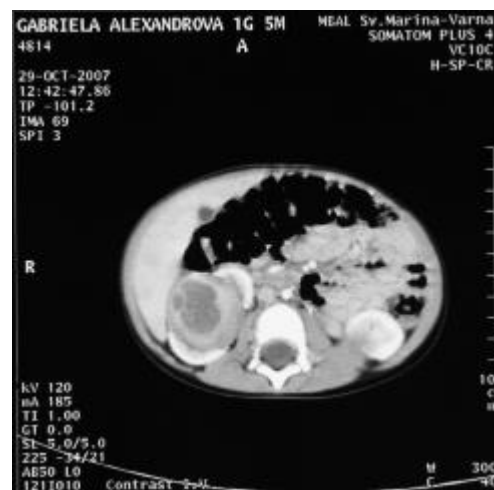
Abdominal CT scan at diagnosis showing large bilateral renal masses
